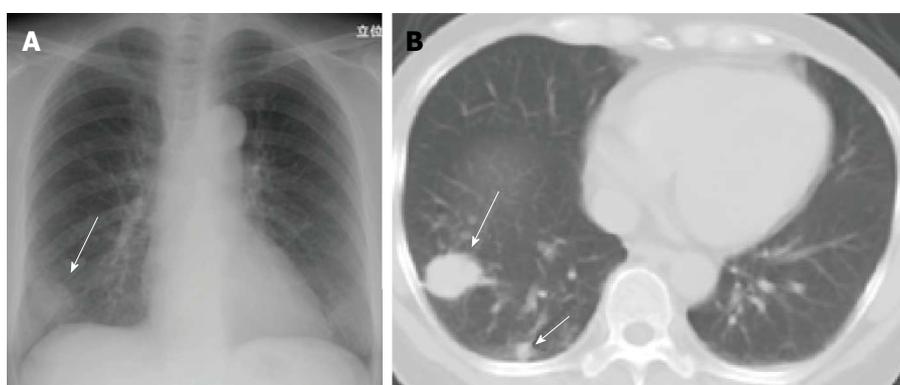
Cryptococcus neoformans* pneumonia in a woman in her 50s. A: Chest radiograph shows a mass in the right lung base (arrow); B: Chest computed tomography with a 5 mm slice thickness shows a mass and nodule in the right lower lobe (arrows). Multiple nodules/masses in the same pulmonary lobe are considered characteristic findings of *Cryptococcus* pneumonia.
